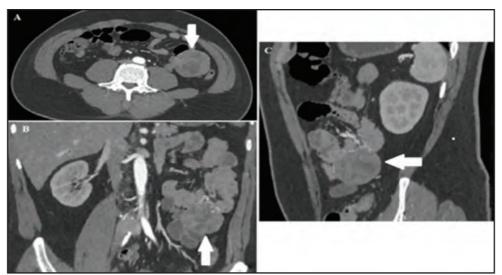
CT abdomen showing axial (A), Coronal (B) and Sagittal (C) of tumour arising from small bowel (white arrow).
